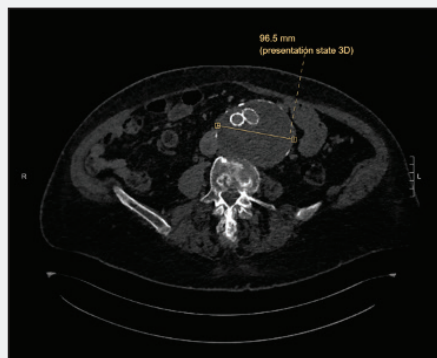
CT image demonstrating a 9.6-cm expanding aneurysm.
